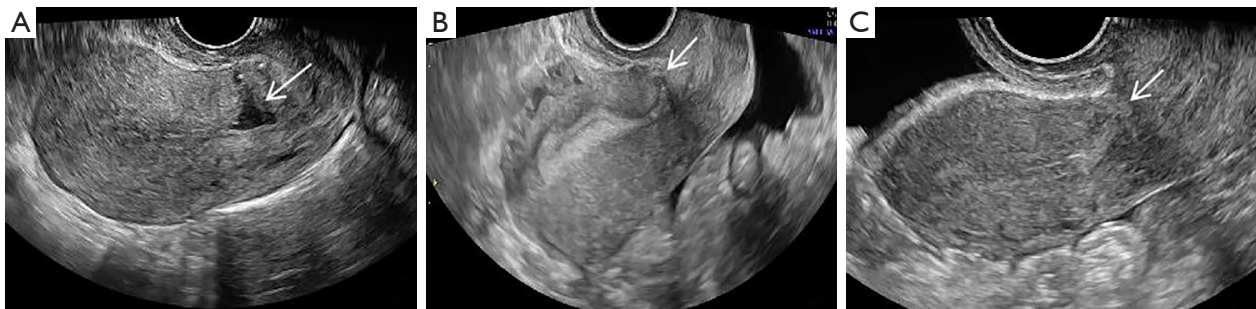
Ultrasound images of the uterus from the same woman at (A) 6 weeks, (B) 6 months, and (C) 12 months postpartum. The white arrows show the caesarean section scar of the uterus, the presence of a defect in (A), and absence of (A) defect in (B) and (C).
